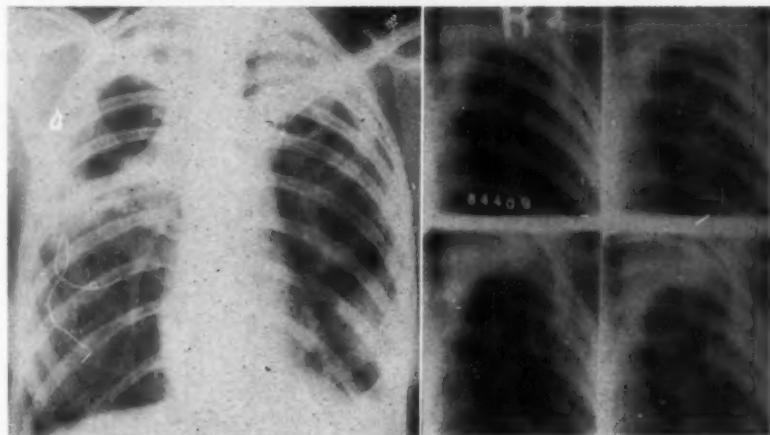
Chest roentgenogram (and tomograph films at 4, 5, 6 and 7 cm levels from the posterior chest wall) January 28, 1958.
